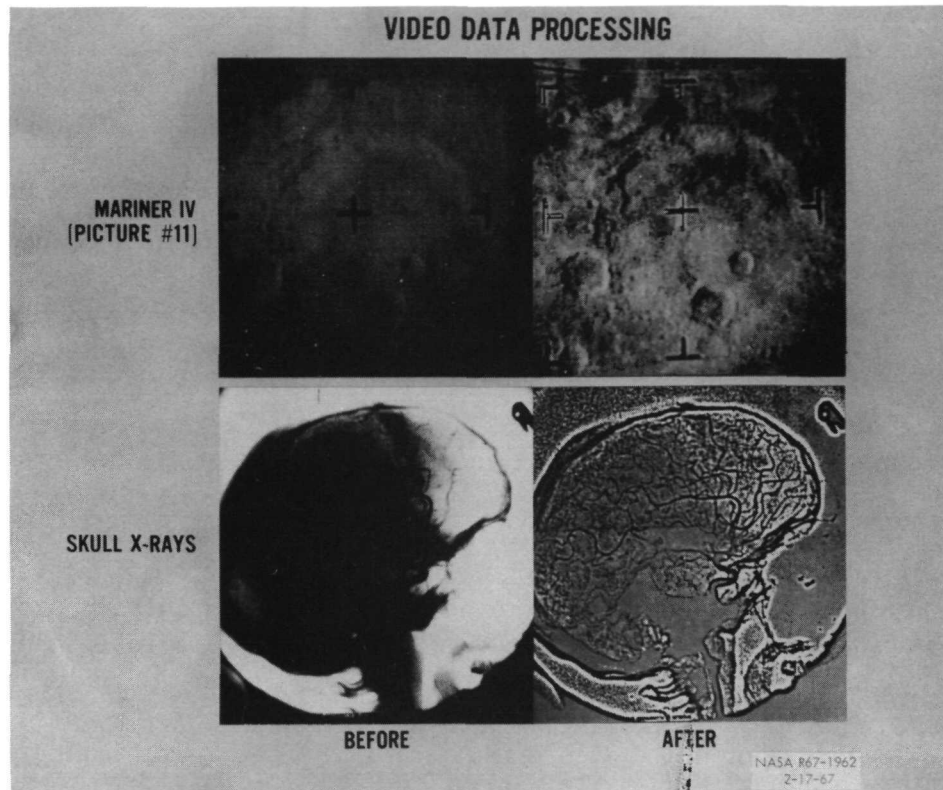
An Example of Aerospace technology developed for one purpose--image enhancement of photographs from outer space, -- applied to solve a biomedical problem -- improved resolution of X-rays for medical diagnosis.
